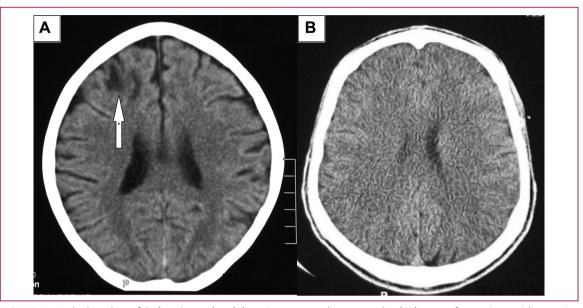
Brain imaging of ischemic stroke. (A) Brain computed tomography (CT)-scan of a patient with anterior cerebral artery ischemia, shown by the white arrow, associated with cortical atrophy compared to (B) normal brain CT-scan of same age.
